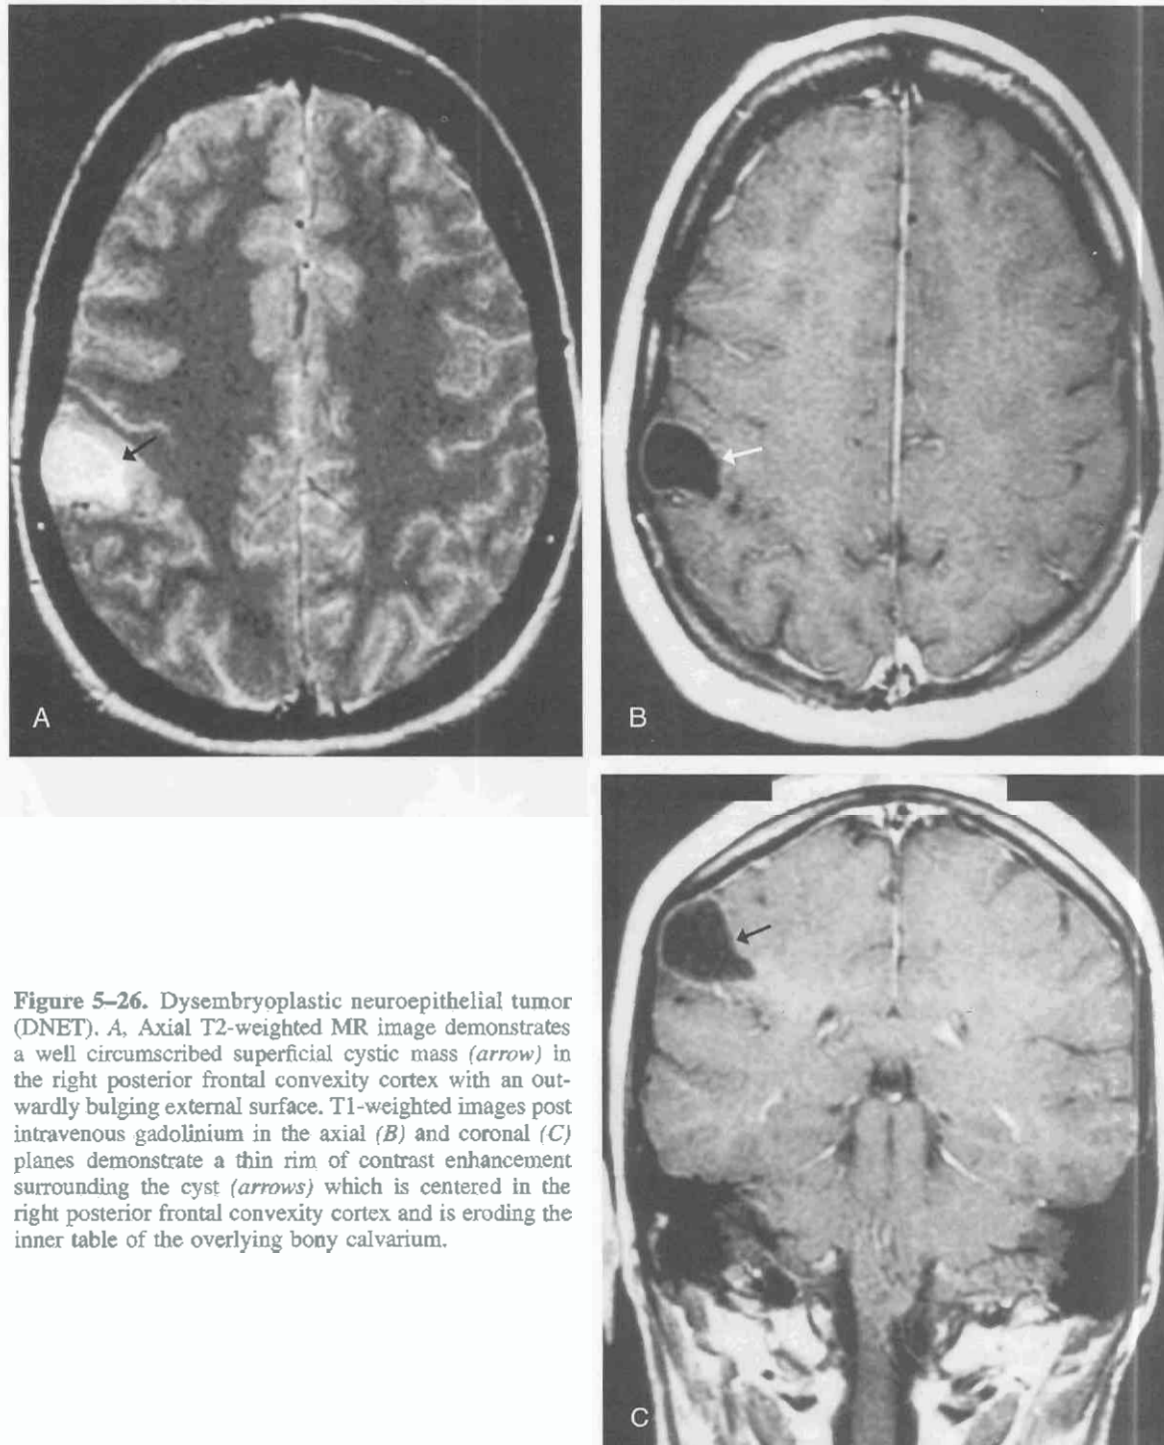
Dysembryoplastic neuroepithelial tumor (DNET). A, Axial T2-weighted MR image demonstrates a well circumscribed superficial cystic mass (arrow) in the right posterior frontal convexity cortex with an outwardly bulging external surface. T1-weighted images post intravenous gadolinium in the axial (B) and coronal (C) planes demonstrate a thin rim of contrast enhancement surrounding the cyst (arrows) which is centered in the right posterior frontal convexity cortex and is eroding the inner table of the overlying bony calvarium.
